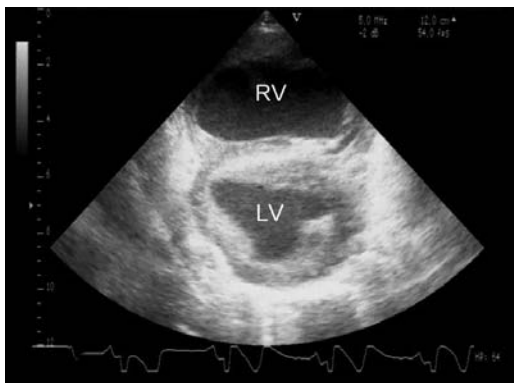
Right parasternal short-axis view at the level of the papillary muscles at end diastole. Dilatation of the right ventricle (RV) and hypertrophy of the right ventricular wall. Note the flattened septum interventriculare, showing pressure overload of the right ventricle. LV = left ventricle.
